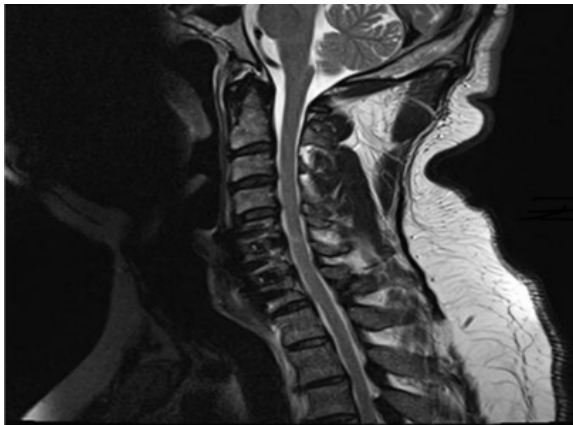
Post operative.T2-weighted sagittal done after 8 months. showed complete elimination of previously noted disc on C5-C6, C6-C7 With a small area of high signal intensity opposite to C5-C6 disc level
